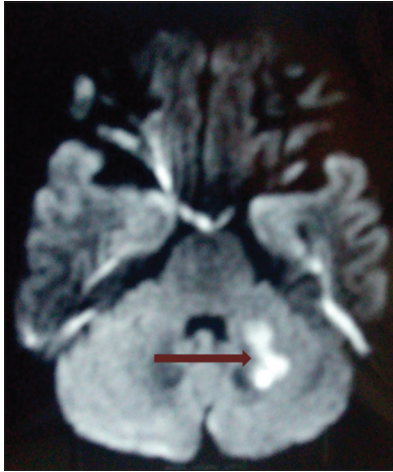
DWI image showing restricted diffusion in left cerebellar hemisphere suggestive of infarct
